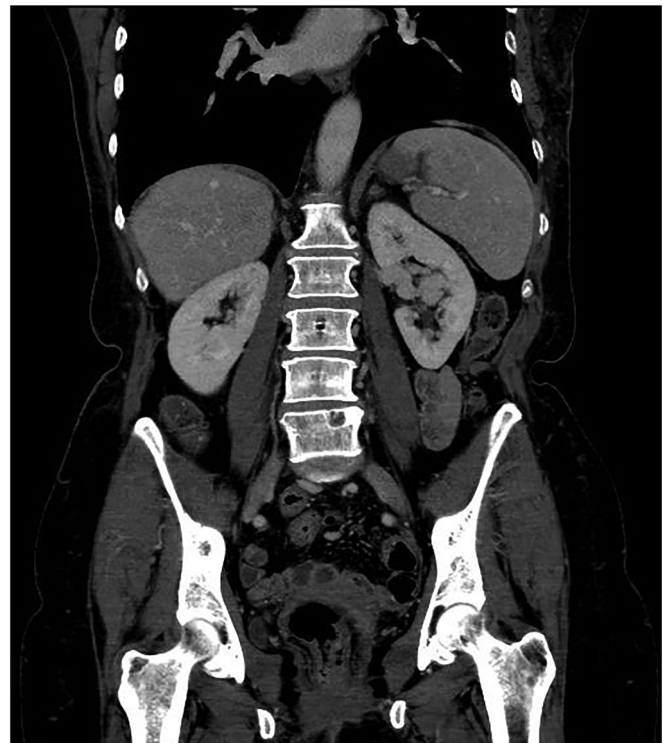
Coronal reconstruction of contrast enhanced CT scan in nephrographic phase showing on the left side an enlarged, draining vein in the central part of kidney hilum.
